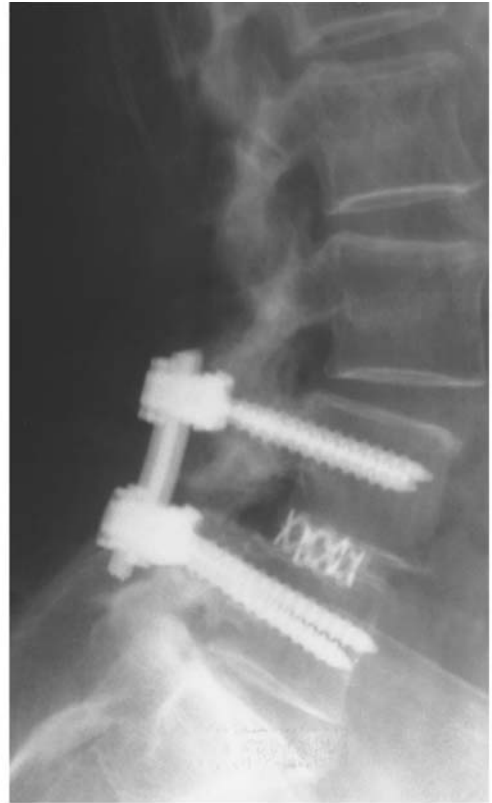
(A,B) Preoperative lumbar spine AP and LL roentgenogram views showing degenerative spondylolisthesis in a 68-year-old retired woman affected by neurogenic claudicatio intermittens and right L5 and S1 radiculopathy at rest. A severe central and lateral stenosis was observed at the L4-L5 and L5-S1 levels in the preoperative CT scans (not reported here). She was scheduled for L4-L5 and L5-S1 decompression by laminotomy and lateral recess enlargement, and instrumented interbody fusion. (C,D) Postoperative lumbar spine AP and LL roentgenogram views showing decompression and interbody fusion instrumented by non-threaded mesh cages and polyaxial transpedicular screws (Moss[®]-Miami System). Note the L4-L5 intervertebral disc space increase and the foraminal clearance that did not require foraminotomy at this level. Bone graft were impacted in front of the mesh cages as described in the original surgical technique to help monitoring fusion in the postoperative time (sentinel graft). The patient is free from low back and lower limb pain at 2-year follow-up.
